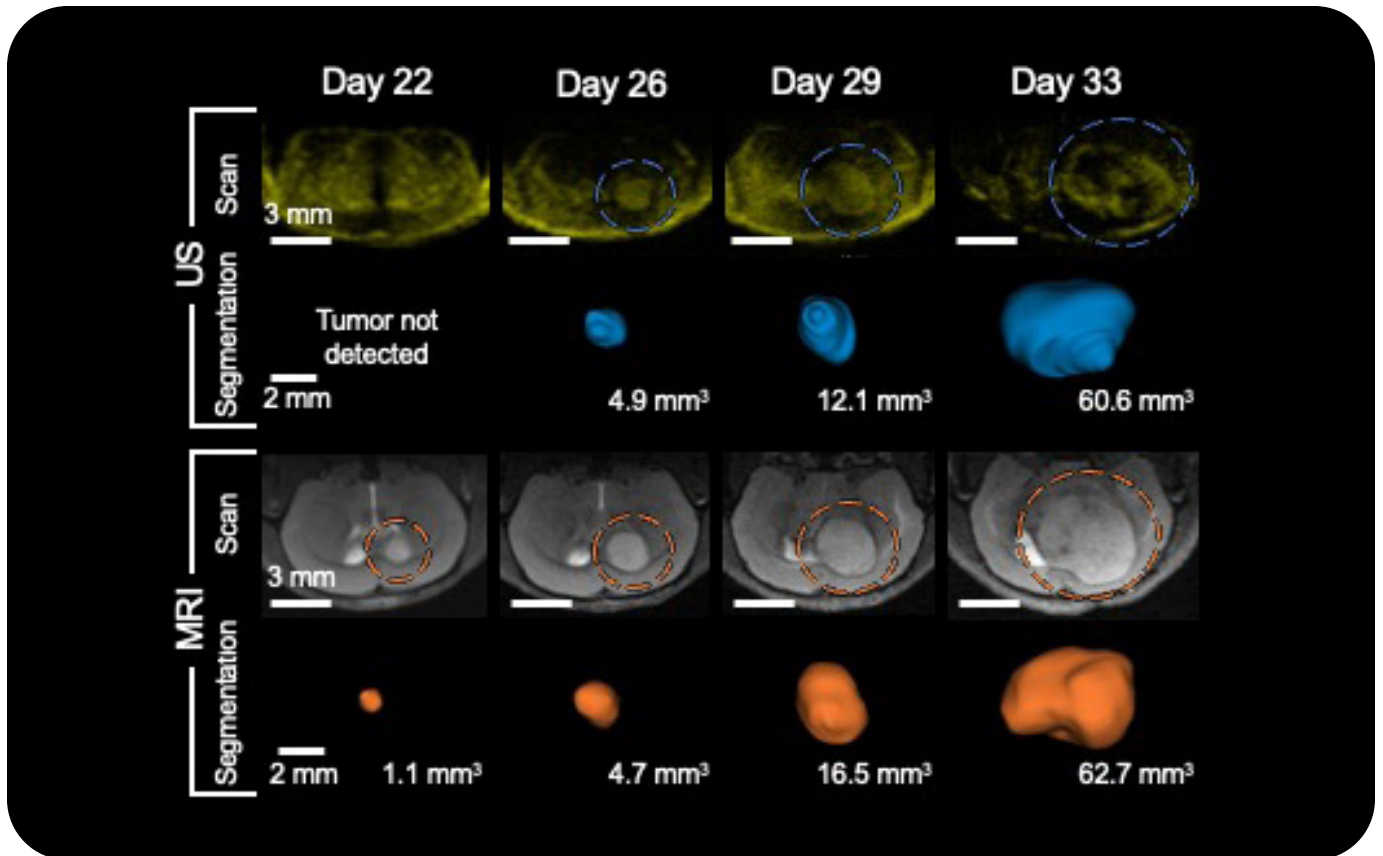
Representative tumor growth images. Representative tumor growth images of ultrasound (top row) and MRI (third row). The 3D rendering of the segmentations are shown in rows 2 and 4 for ultrasound and MRI, respectively. Tumor location is indicated by the dotted circles.
